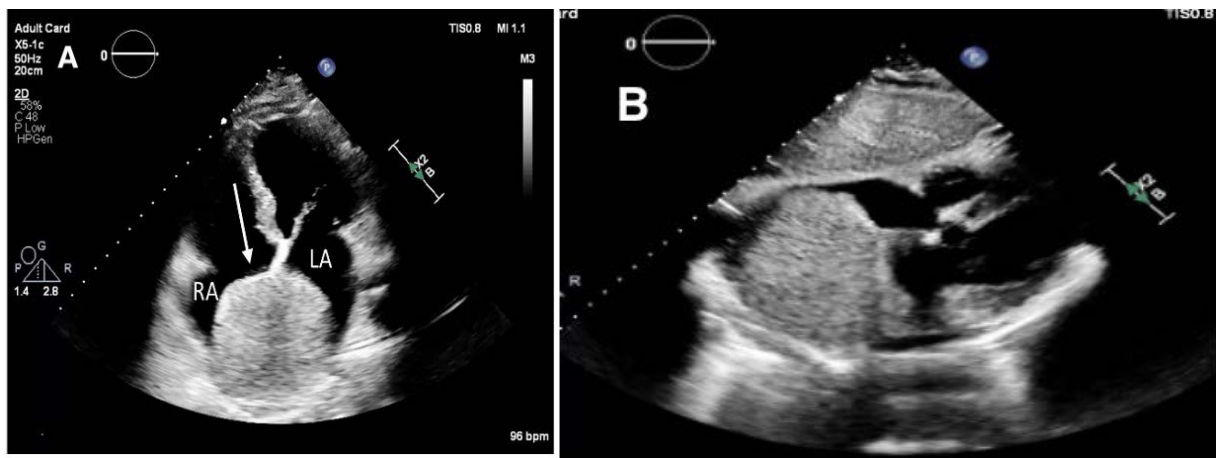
Transthoracic echocardiogram, Apical 4C view (A), and subcostal view (B) show a large (8x6cm), rounded echogenic mass arising from the inter-atrial septum, bulging into both the left and right atria and filling a significant part of both atrial cavities (white arrow). It was 17mm from the atrioventricular valves, not affecting valvular function.
